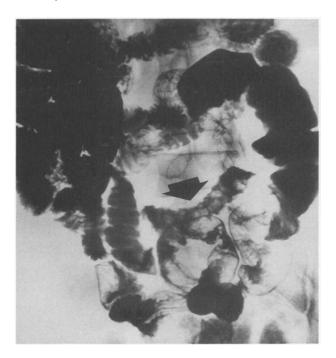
Film from a small bowel ileal x-ray examination, showing "cobblestoning" of the terminal ileal mucosa and indicating the presence of Crohn's disease.
